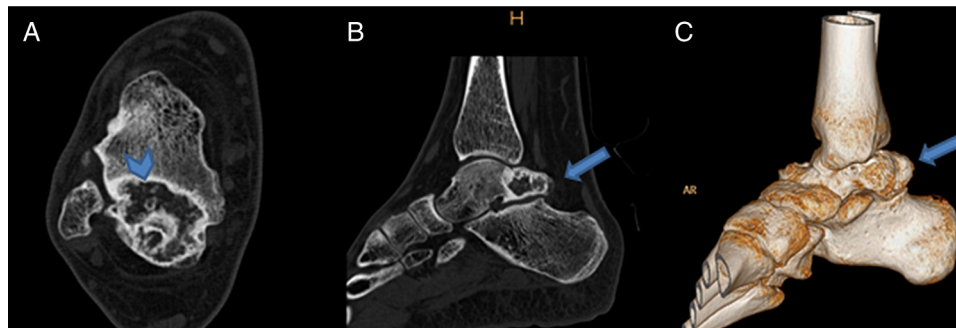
Axial (A), sagittal (B), and volume-rendered (C) noncontrast-enhanced computed tomography scans of right ankle (bone window) showing osseous outgrowth (arrows in B and C) arising from the posterior and medial aspect of the talus. Ring and arc-like calcifications can be seen within the lesion (arrowhead in A).
